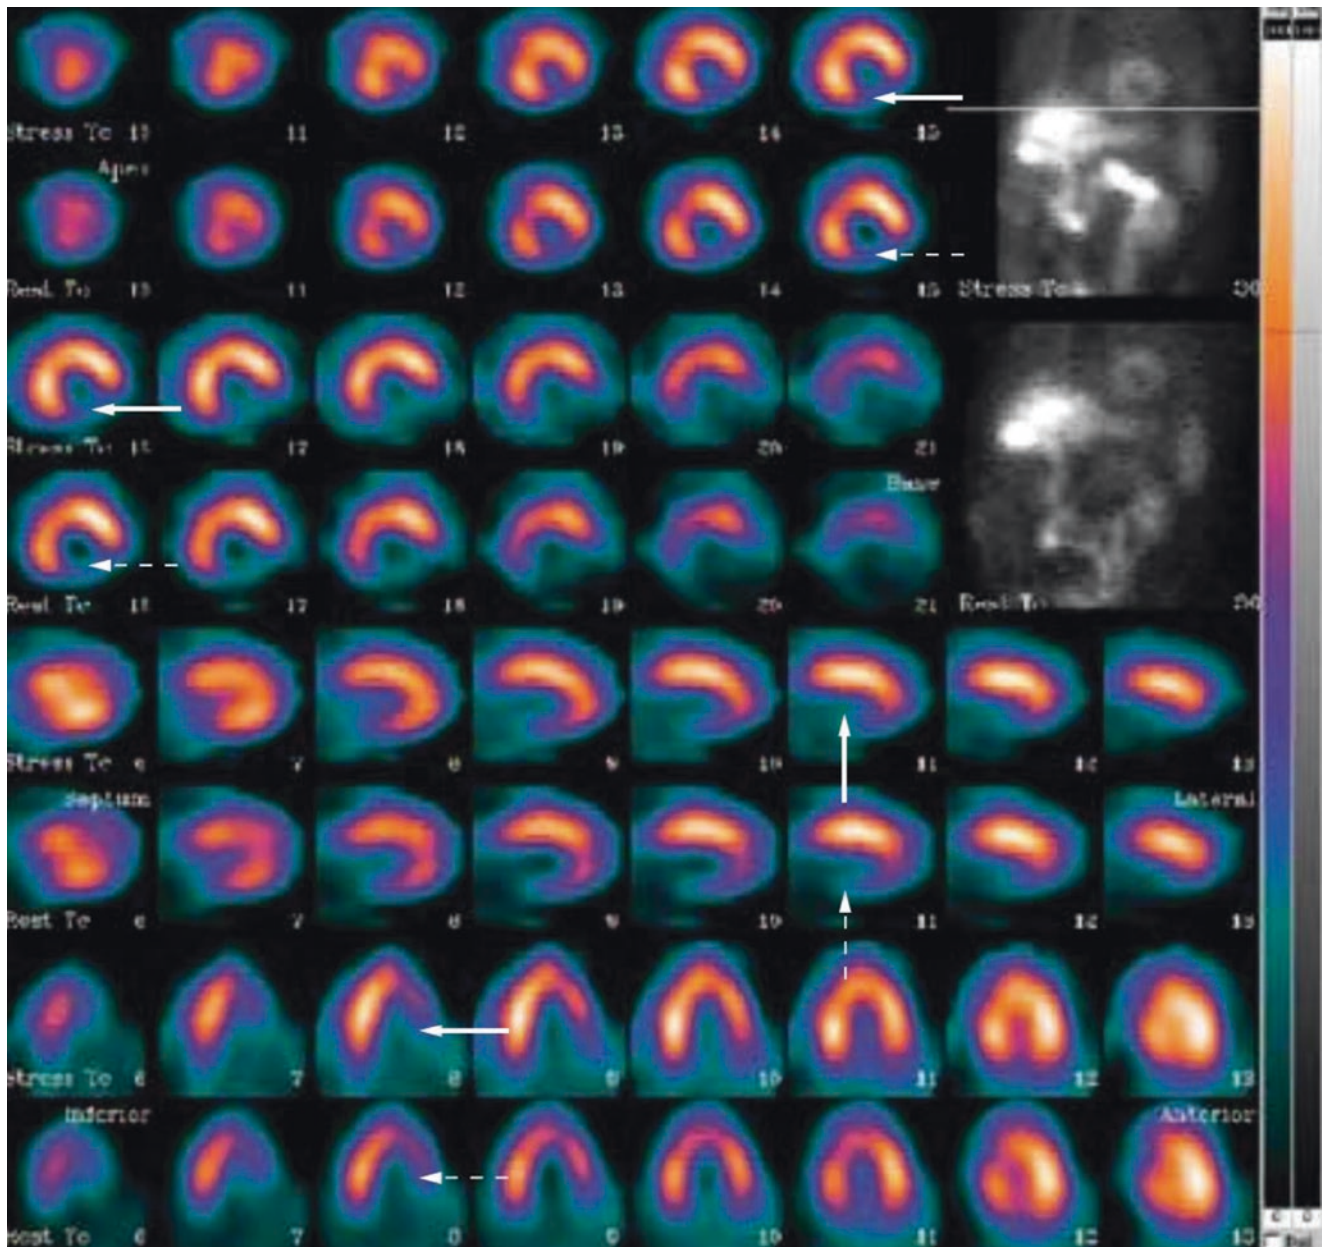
Tc—SPECT imaging showing a fixed perfusion defect in stress (solid arrow) and rest (dashed arrow) imaging of the mid to basal, inferior and inferolateral wall—indicative of scarred, nonviable myocardium
